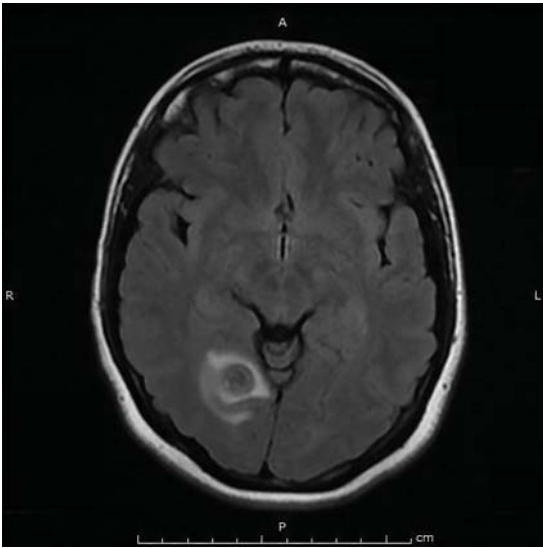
Magnetic resonance imaging 2 months later showed partial resolution of the cystic lesion within the right occipital lobe.
